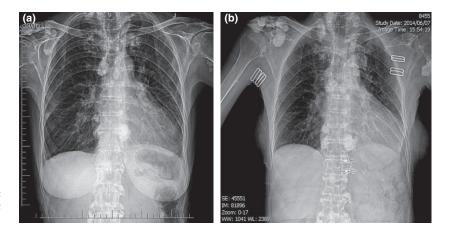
Multiple large calcifications of right shouder on chest X-ray: (a) prior to treatment with Rituximab (2013) and (b) after treatment with Rituximab (2014).
